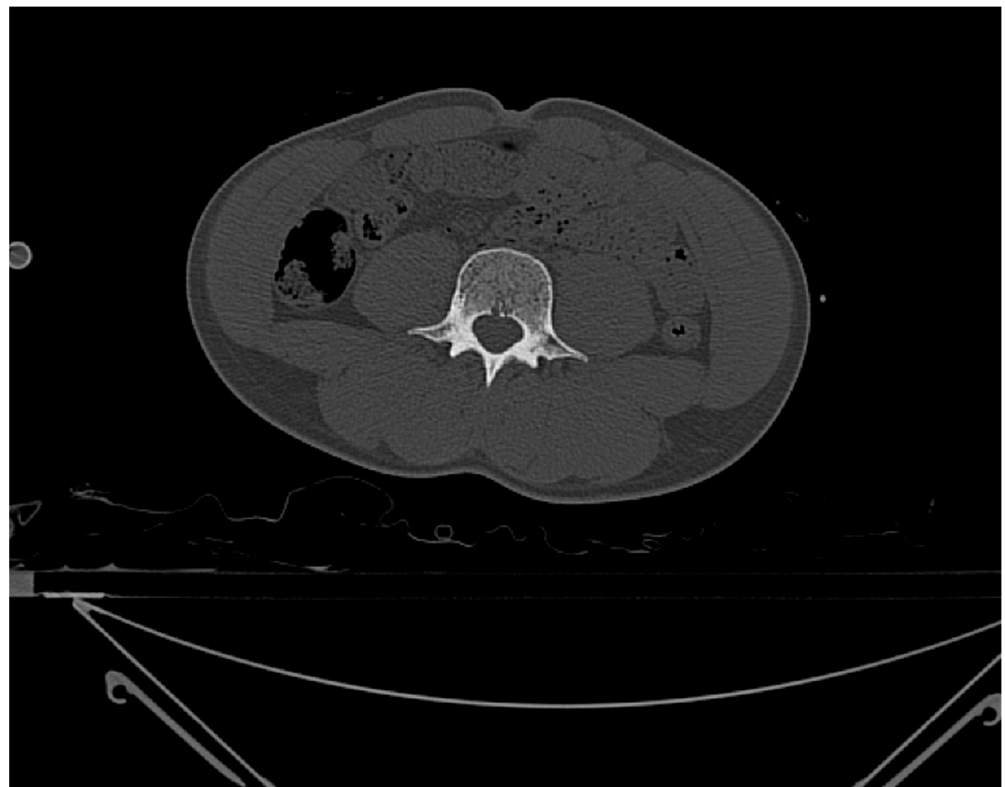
CT slice in the transverse plane from ID 105469 used to measure vertebral densities. Reprinted with permission from [16].
